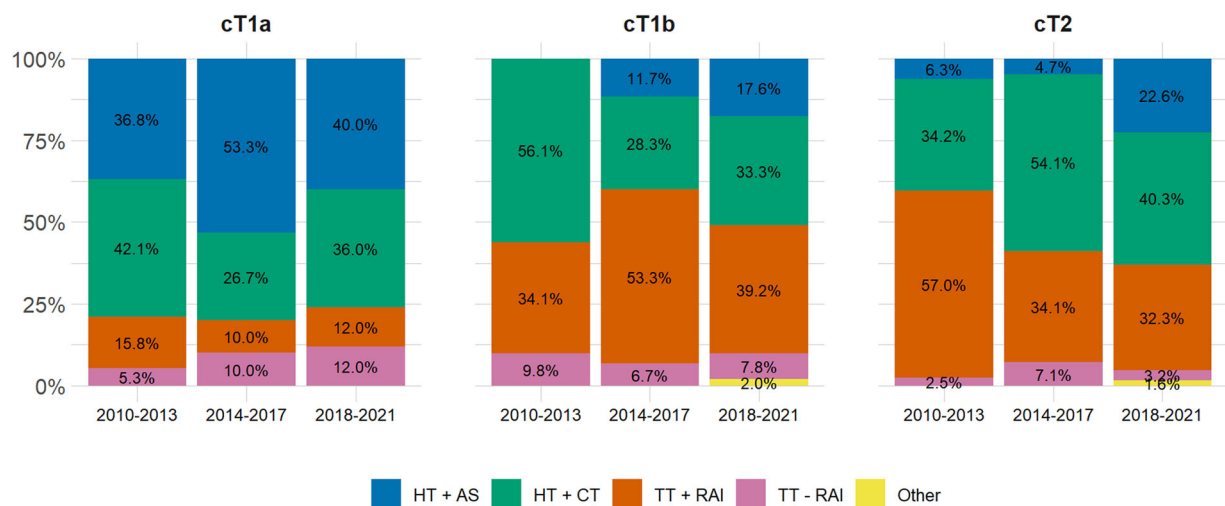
Trends in the treatment of low-risk papillary thyroid carcinoma. AS, active surveillance; CT, completion thyroidectomy; HT, hemithyroidectomy; RAI, radioactive iodine treatment; TT, total thyroidectomy.
